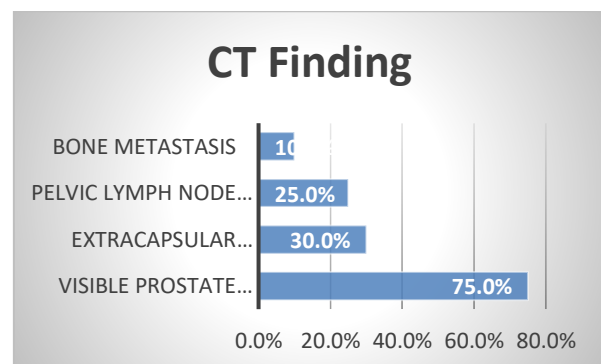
Distribution of CT Scan Findings Among Patients with Prostate Cancer (n = 100)
